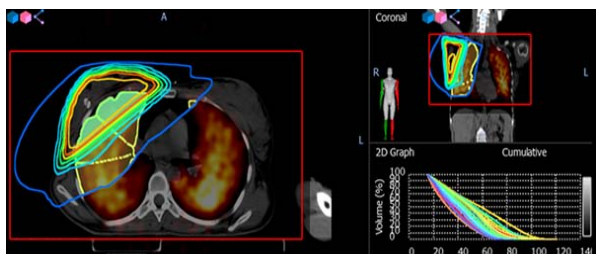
Fusion of single photon emission computer tomography (SPECT) based lung perfusion scintigraphy (SLPS) images and radiotherapy plans via VelocityAI® programme
